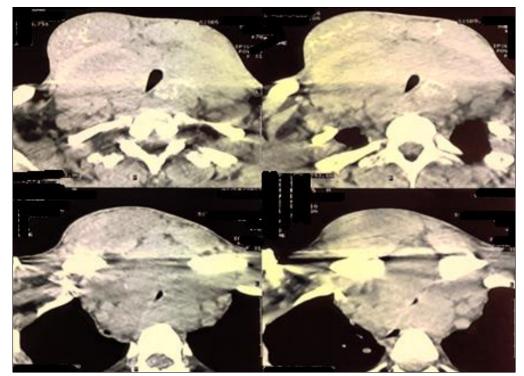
axial CT scan showcasing the voluminous heterogeneous thyroid mass with encompassment with deviation of the trachea towards the left side with repression of the esophagus.
